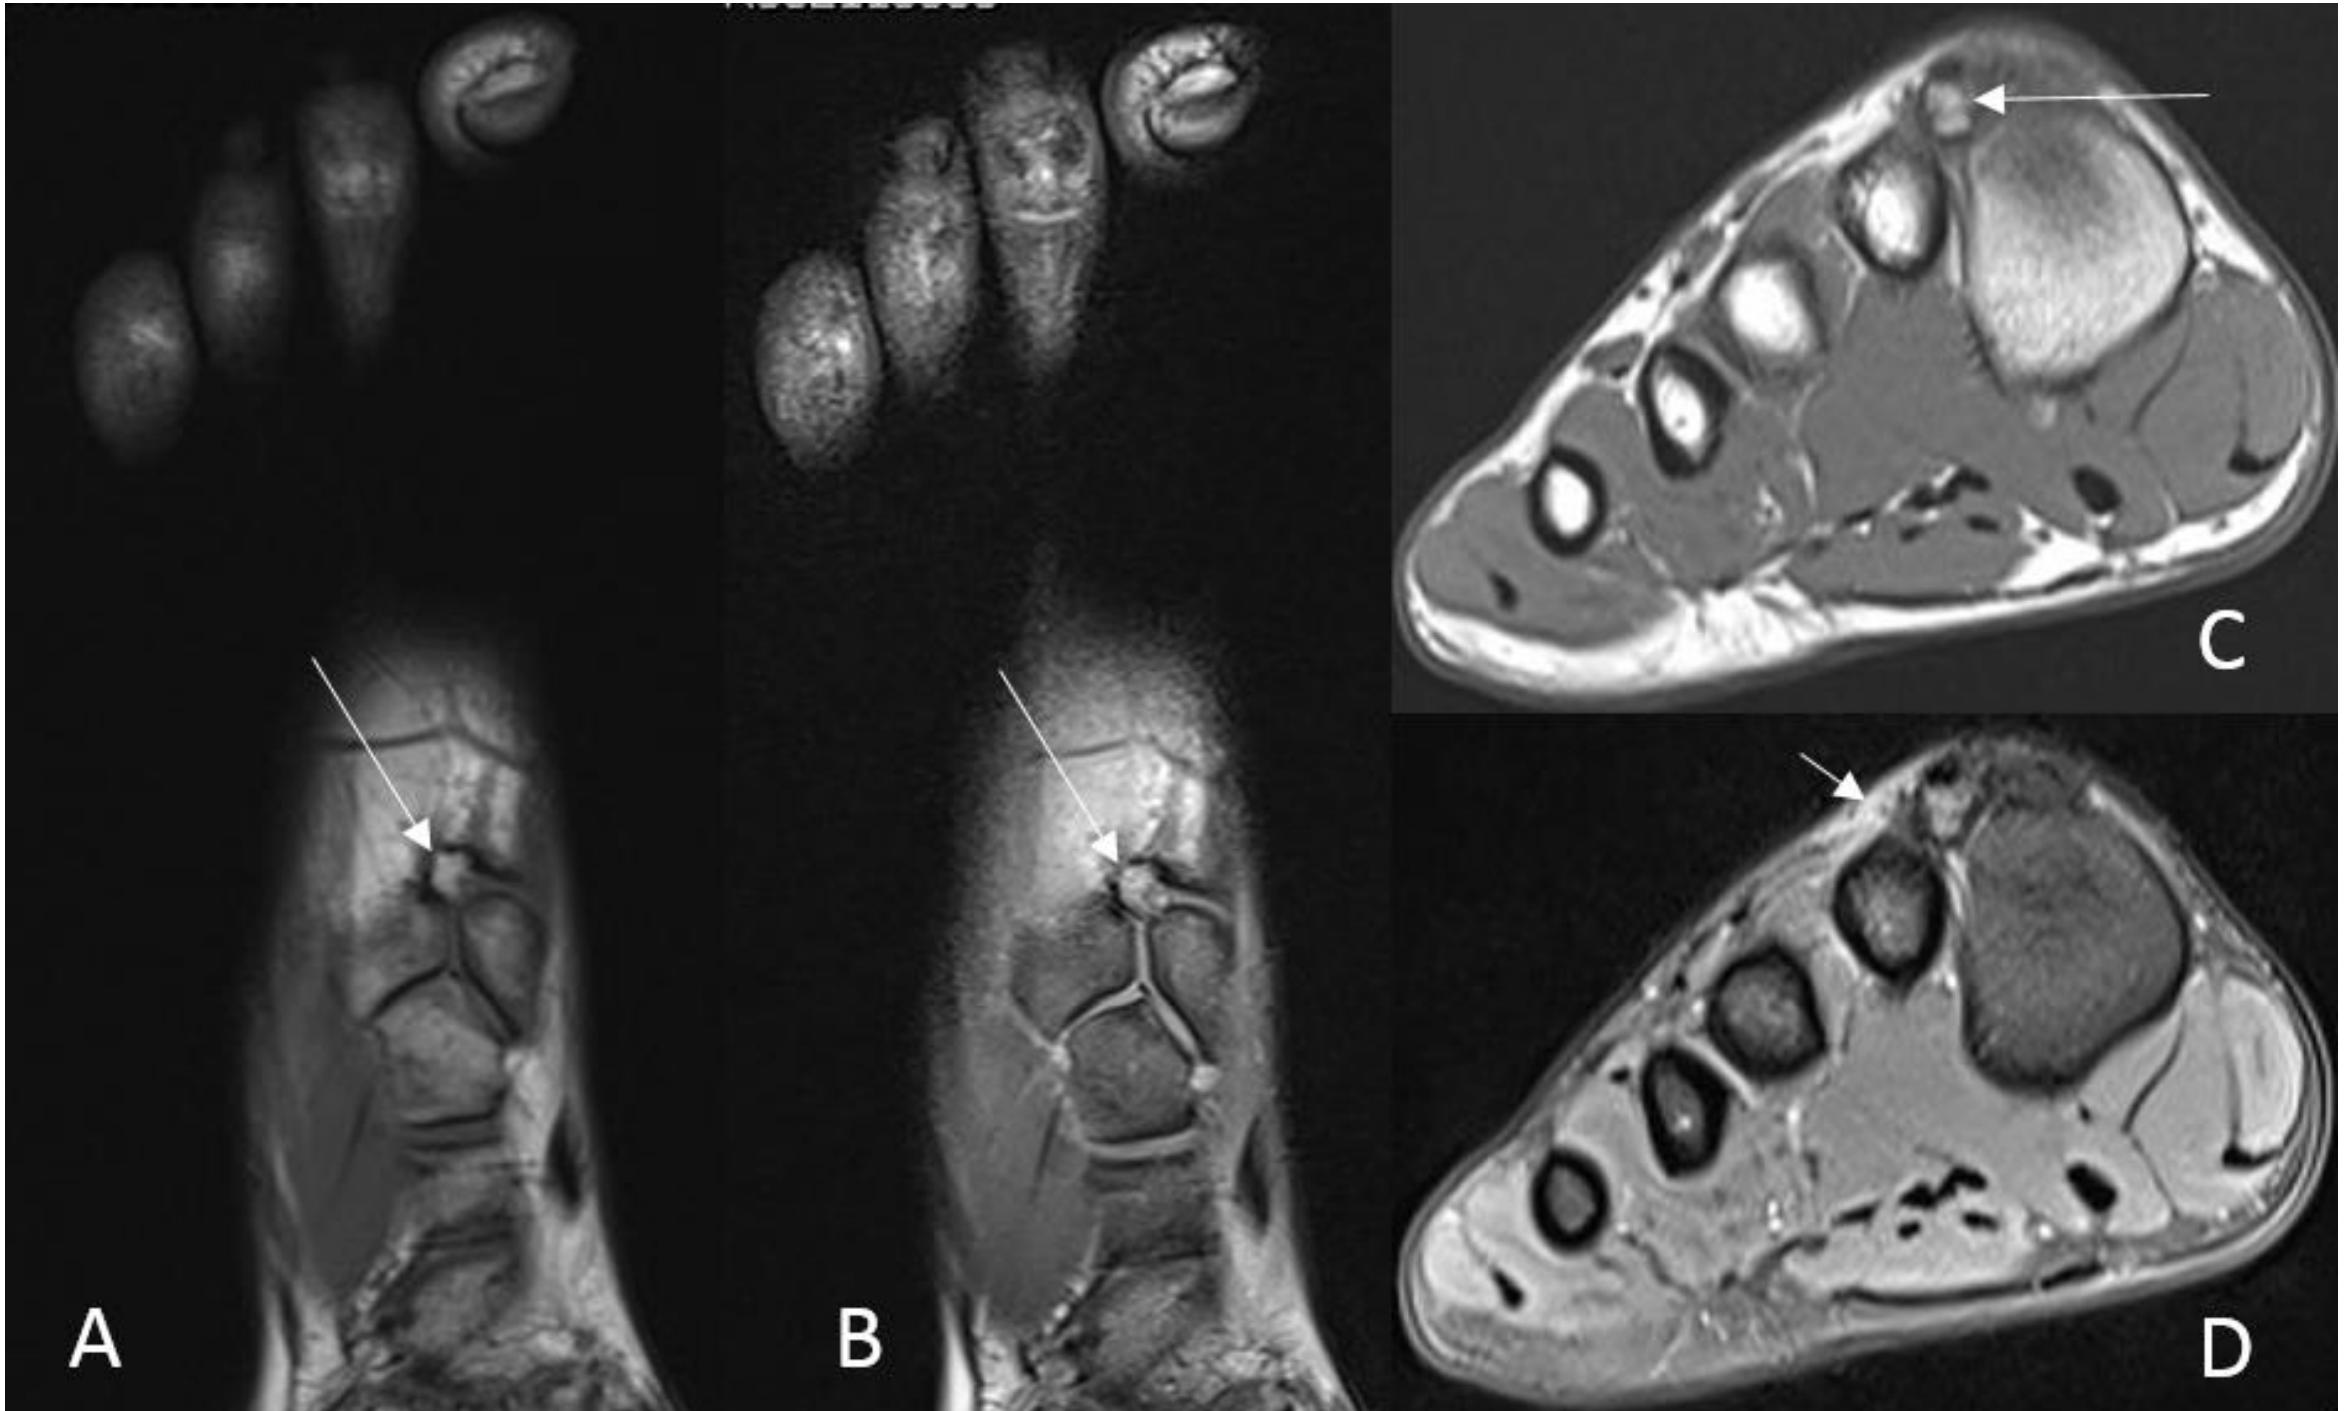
Tarsal os styloideum. MRI of the right foot.
